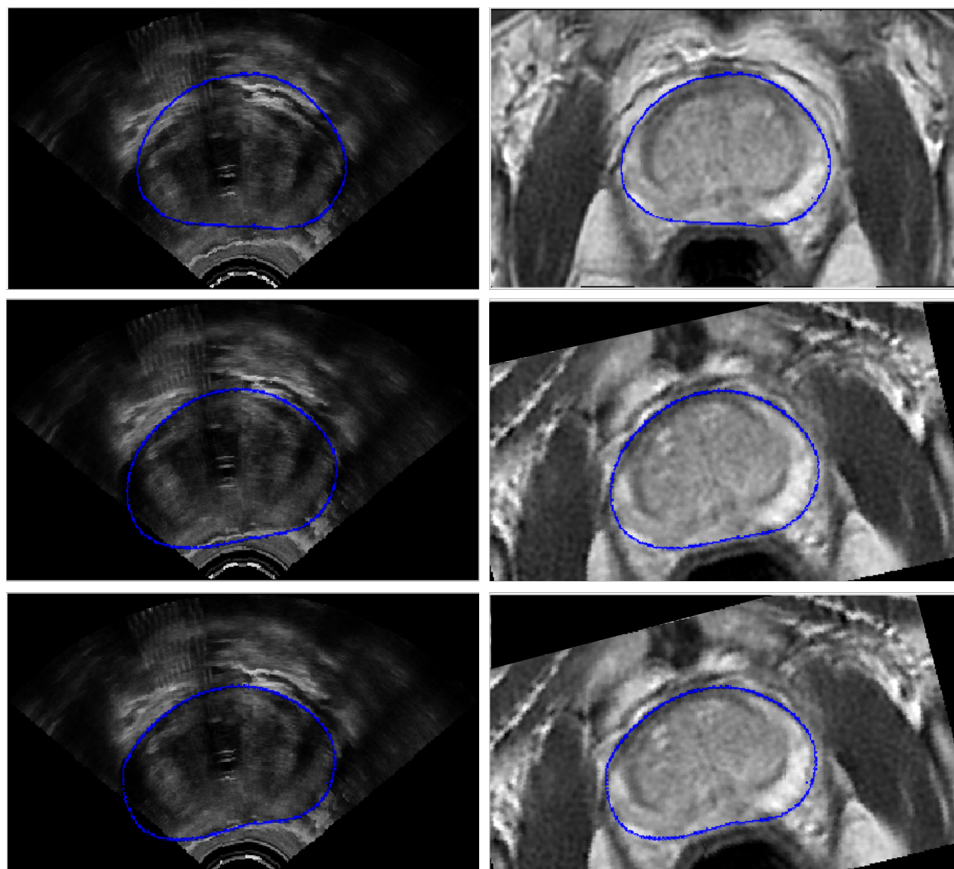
MRI to TRUS volume registration process
